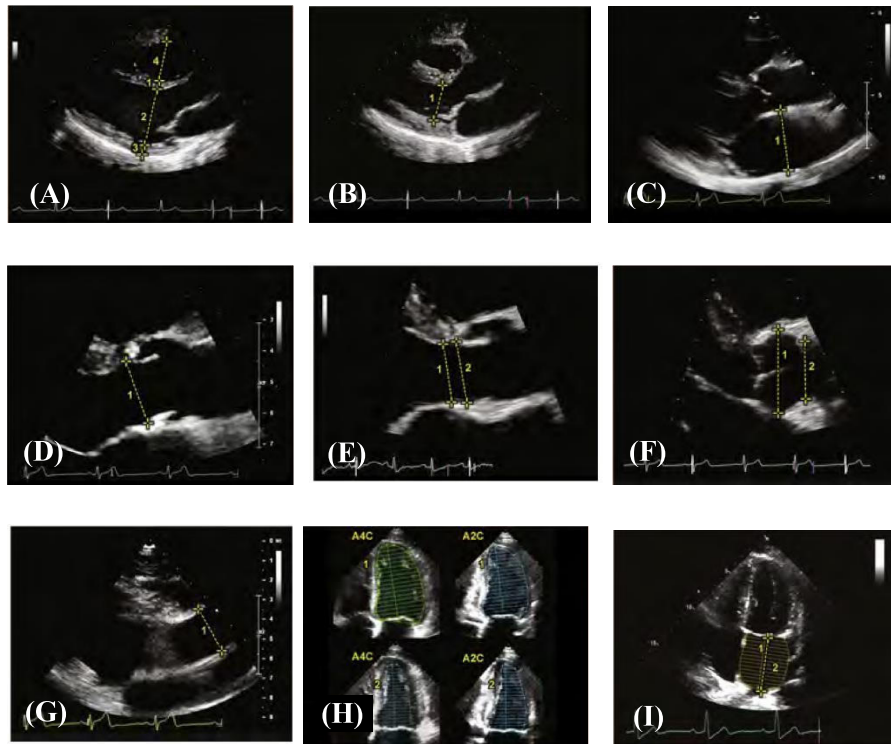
Echocardiographic Measurements: (A) PLAX view, measurements made (in end-diastole): IVSd, LVIDd, LVPWd, and RVD; (B) PLAX view, measurement made: LVIDs; (C) PLAX view, measurement made: LA diameter (D) PLAX view (Zoomed Aortic Annulus), measurement made (in mid-systole): AV annular diameter; (E) PLAX view (Zoomed LVOT), measurement made (in mid-systole): LVOT diameter and AV annular diameter; (F) PLAX view (Zoomed AoV and Asc Ao), measurement made: SoVAo diameter, STJ diameter; (G) PLAX view (Zoomed Asc Ao), measurement made: Diameter of Asc Ao; (H) A4C and A2C views, measurements made (using Biplane disk summation): LV end-diastolic volume, LV end-systolic volume; (I) A4C view, measurements made: LA length and LA area (Mitchell et al., 2019)
